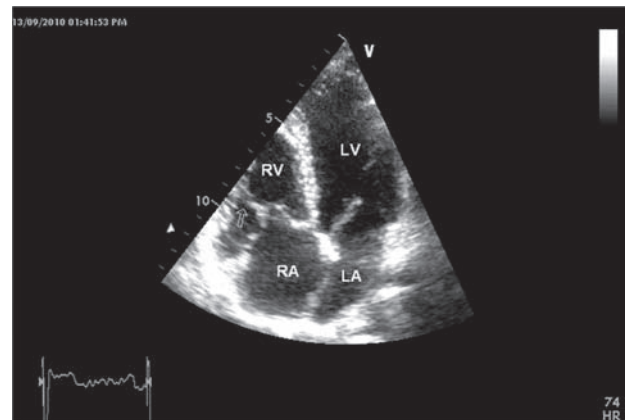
Transthoracic apical four chamber view in end-diastole showing septal and anterior tricuspid leaflets attached to a single short papillary muscle (arrow). LA: left atrial, LV: left ventricle, RA: right atrial; RV: right ventricle.
